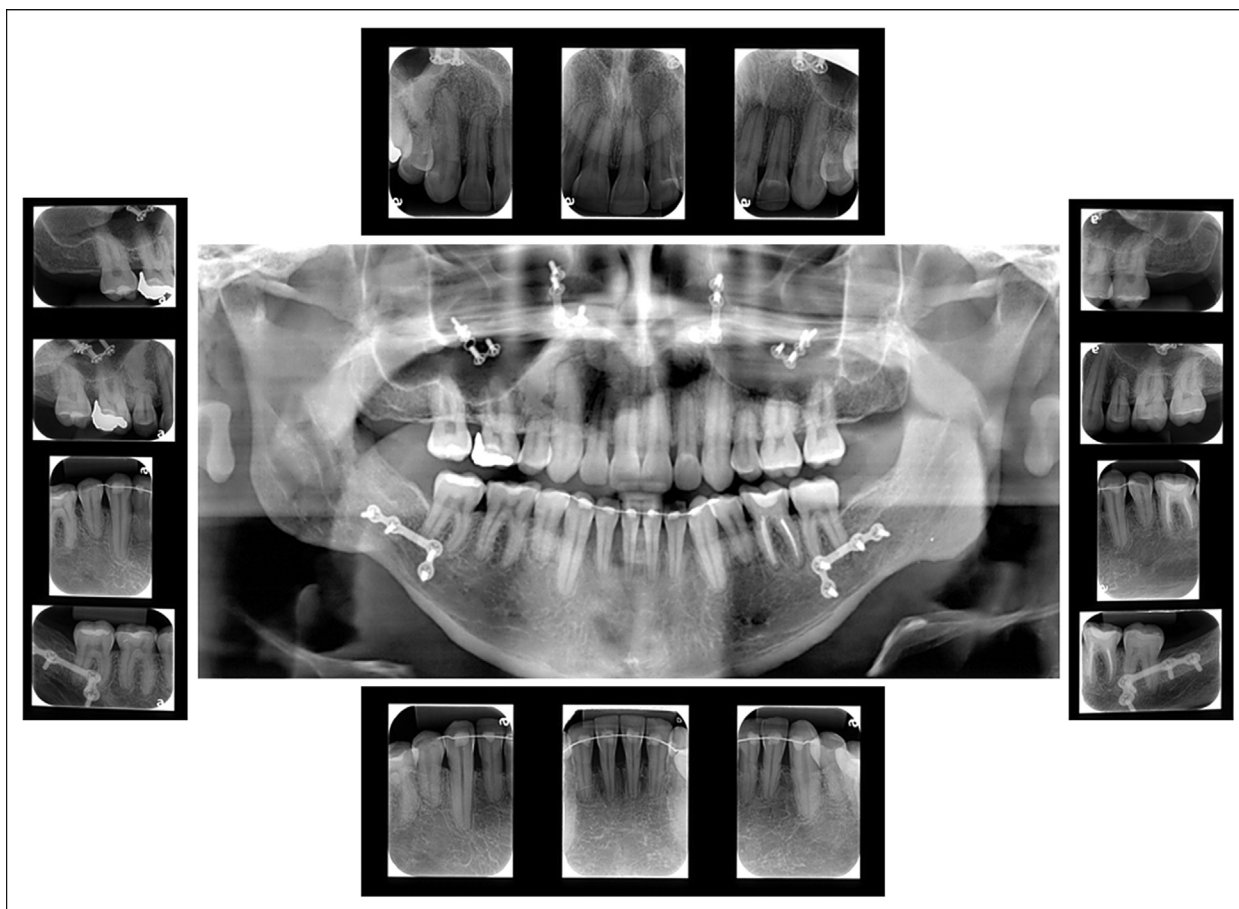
Follow-up panoramic and periapical radiographs.
